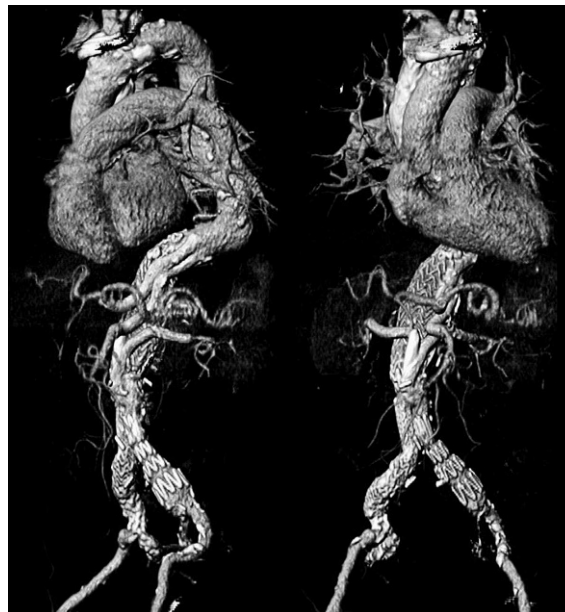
♦ The CT images from patient 5 at 2 years post repair show no endoleak or device migration; the aneurysm has nearly disappeared, and all chimney and periscope grafts are patent.
